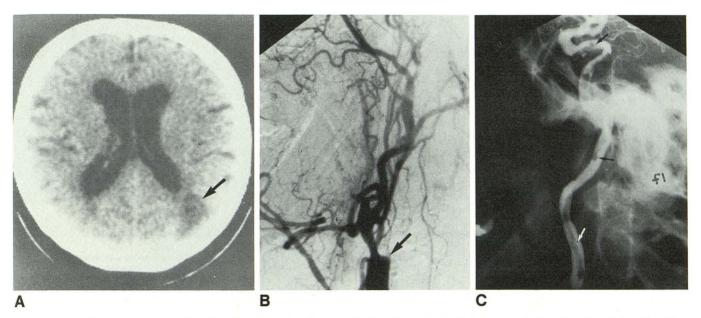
Case 3: 74-year-old man referred for altered mental status lasting 48 hr and associated with transient right lateral hemianopia (see Fig. 1B). A, Admission CT scan shows parietooccipital hypodensity (arrow).
